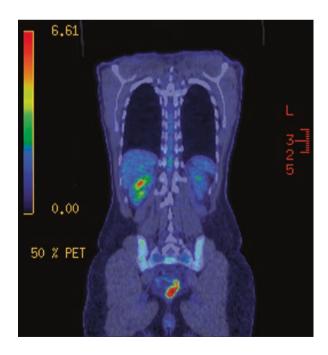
FDG PET-CT scanning showing a locally recurrent rectal cancer with liver metastasis
